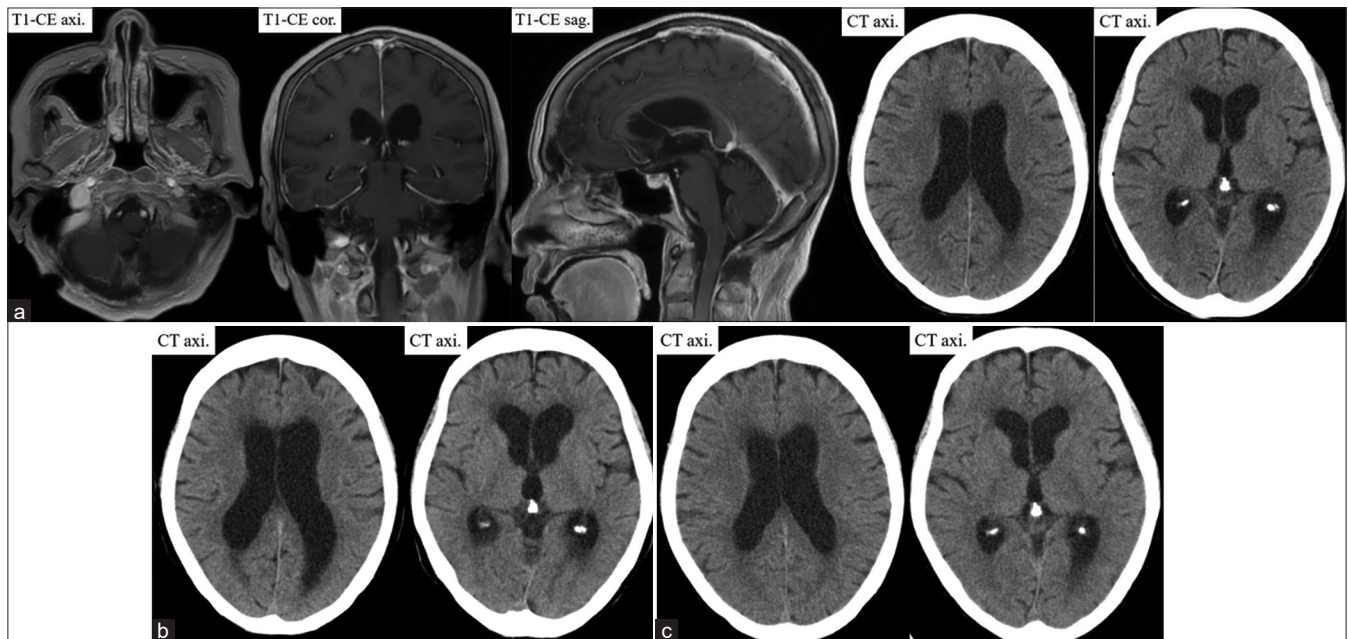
(a) Spinal magnetic resonance imaging showed complete tumor removal, and computed tomography (CT) showed no hydrocephalus (HC) (Evans index: 0.30). (b) CT showed the appearance of HC (Evans index: 0.36). (c) After lumboperitoneal shunt procedure, CT showed improvement in HC (Evans index: 0.32).
